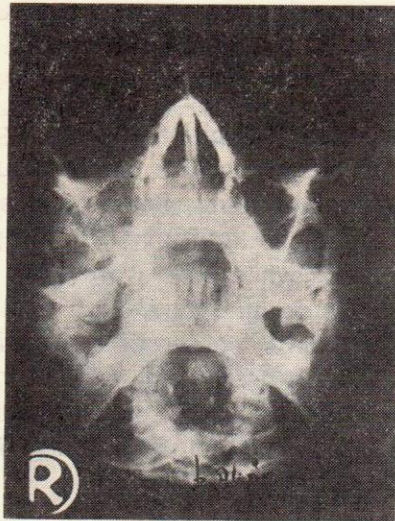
Roentgenogram of the lesion disclosed a wide opacity in the right maxilla and maxillary sinus, destruction of the neighboring bones.
